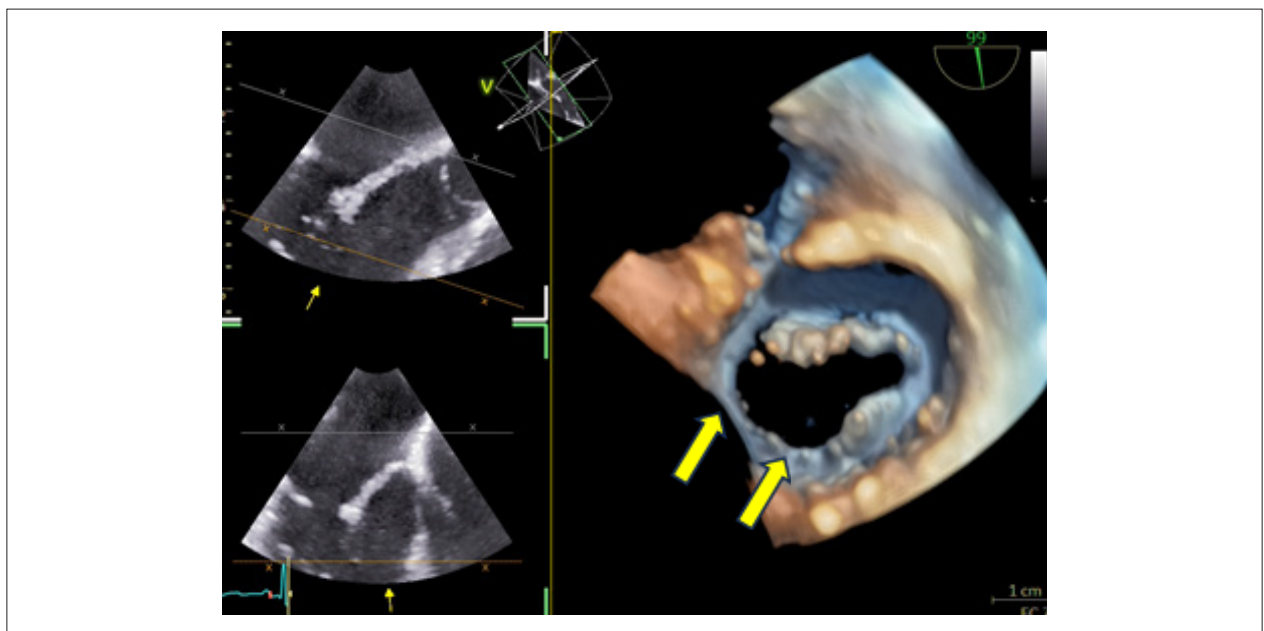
Three-dimensional transesophageal echocardiography with ventricular view of the mitral valve demonstrating partial posterior leaflet hypoplasia (segments P2 and P3 – yellow arrows).
